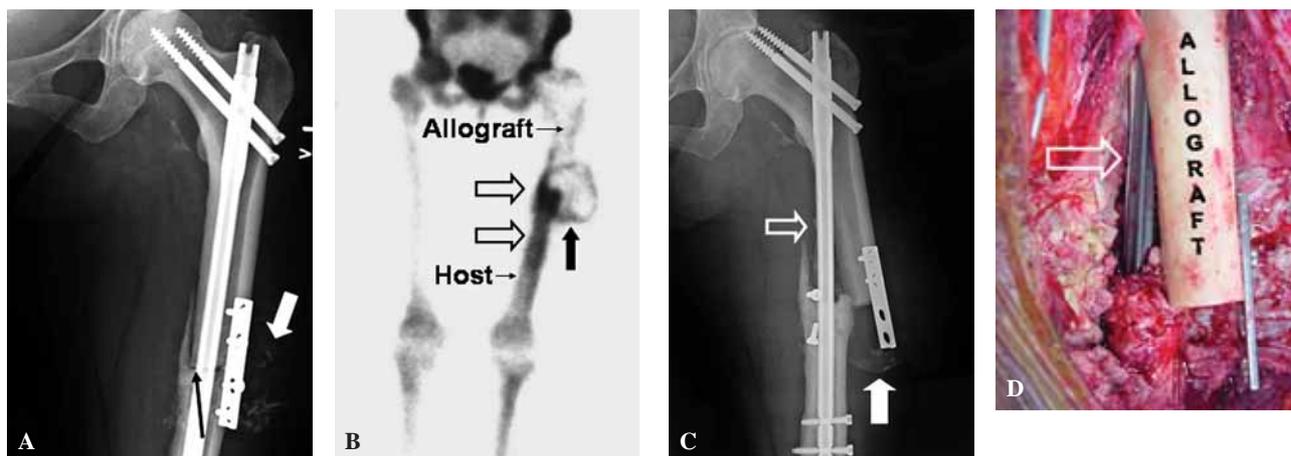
Radiographs of Case 4. Radiographs of a thirty-six-year-old female patient with allograft-host nonunion following proximal femoral allograft transplantation. A. Postoperative radiograph four weeks following the application of 7mg of rhBMP-7 and morselized allografts (white solid arrow) around the allograft-host junction nonunion site (black arrow). B. ^{99m}Tc bone scintigraphy at 6 months demonstrate increased uptake in the callus originating from the host bone (open arrow), in the host bone (open arrow) and in the soft tissue (solid arrow). C. Radiograph 11 months following treatment with rhBMP-7 demonstrates marked resorption on the medial aspect of the allograft (open arrow) and allograft fracture (solid arrow). D. Intraoperative photograph demonstrating resorption of the medial cortex of the allograft and fracture through the allograft (arrow).
